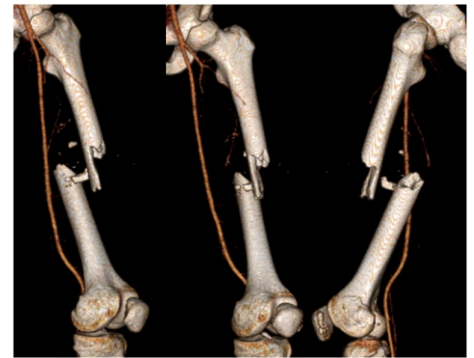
Multiple three-dimensional computed tomography reconstruction images of patient B's left femur demonstrating a comminuted mid-shaft femur fracture with a missing piece of cortical bone.
